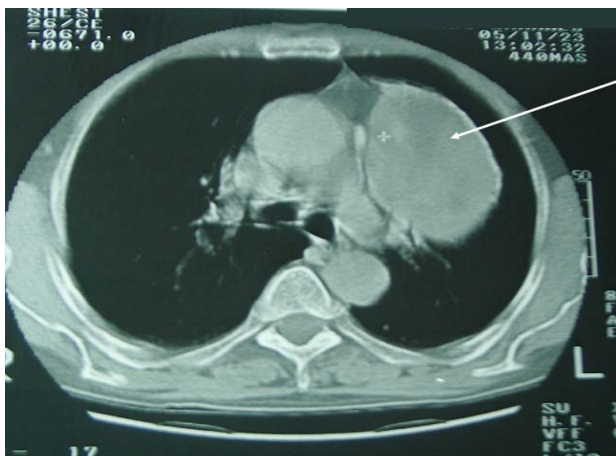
CT-scan demonstrating a mass in the left upper lobe (white arrow)
